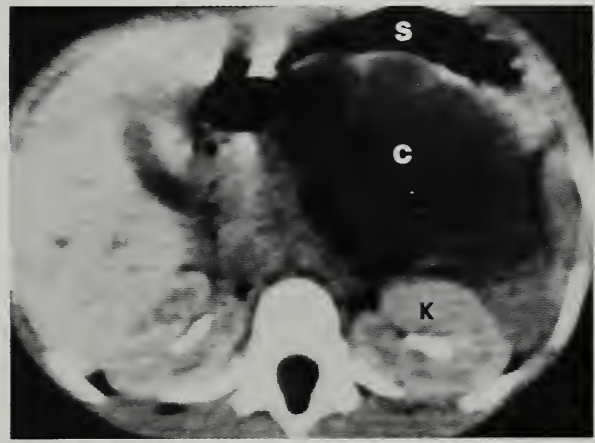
This 6-year old girl presented with an abdominal mass. An abdominal computed tomography showed a low density mass (C) resting behind the stomach (S) and in front of the left kidney (K). A diagnosis of pseudocyst of the pancreas was confirmed at surgery and a history of child abuse with abdominal trauma, occurring ten weeks earlier, was obtained.
